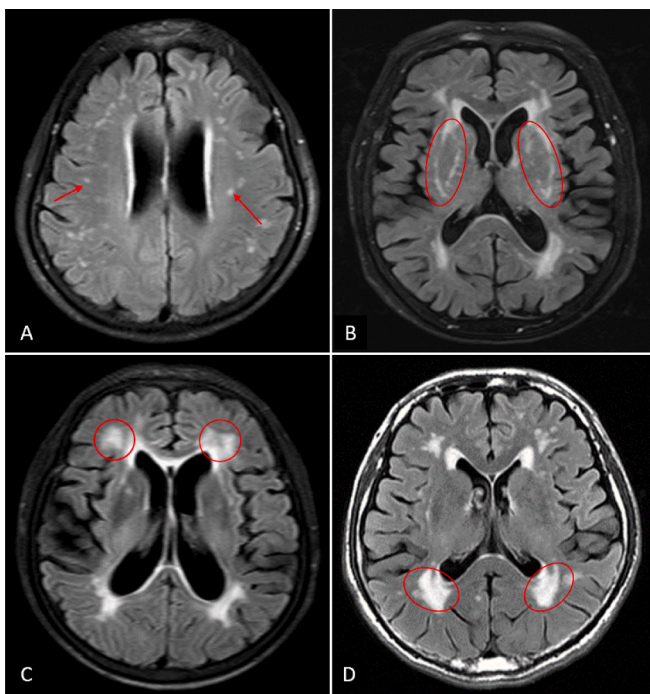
Different WMH patterns on T2 FLAIR MRI: multi-spots pattern (A), *peri*-BG pattern (B), anterior SC patches pattern (C), posterior SC patches pattern (D).
